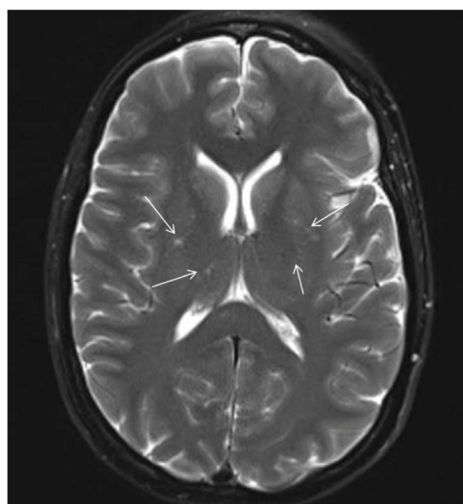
“Starfield pattern” demonstrated on T2-weighted brain Magnetic Resonance Imaging (MRI).
